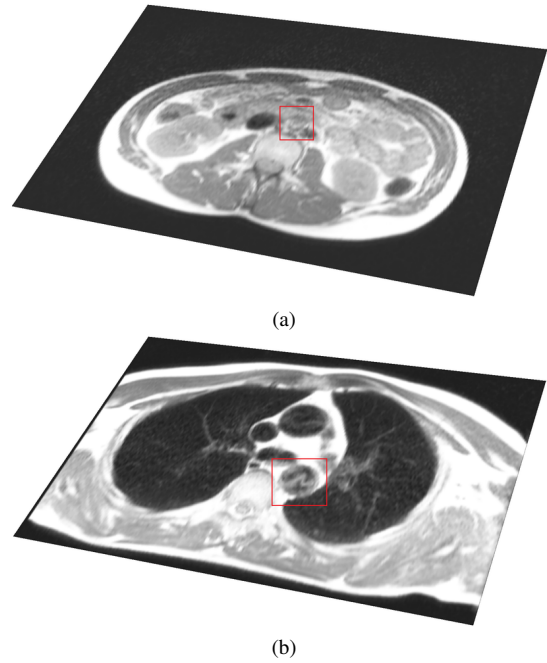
Examples of artifacts found in “black-blood” MRI images marked in red: (a) aorta not visible in transversal slice, (b) noise in the aorta due to heart motion.
